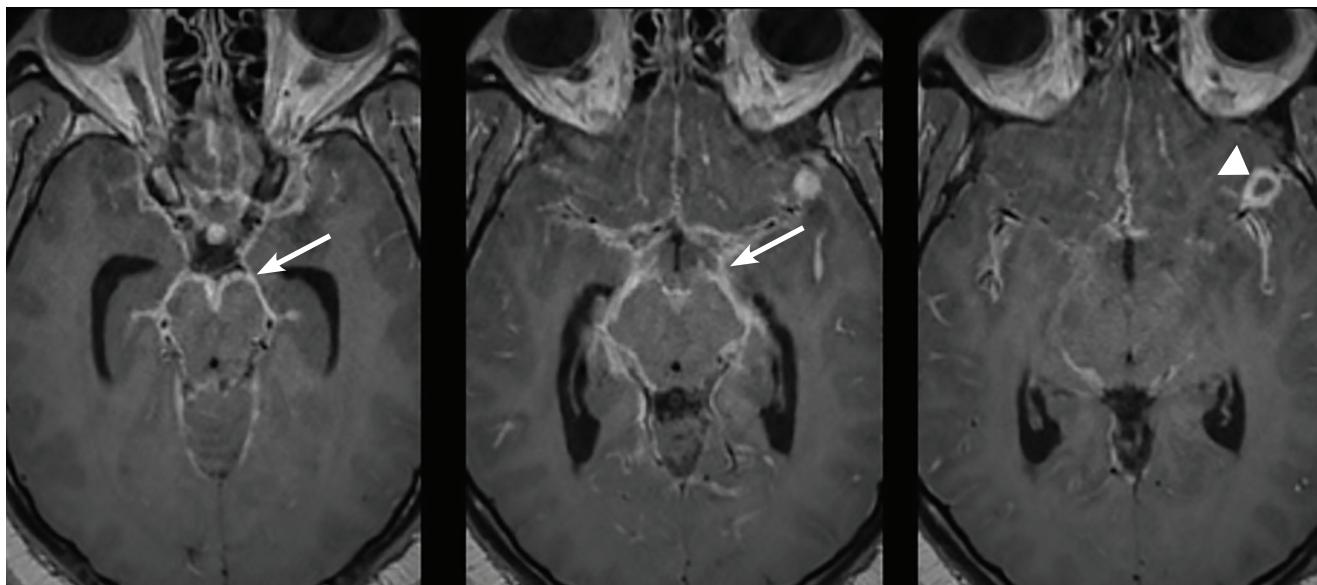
Two weeks later, with the patient’s condition continuing to worsen, magnetic resonance imaging showed bulky leptomeningeal enhancement (arrows), most prominent at the basal surface of the cerebrum, with a peripherally enhancing 1.2-cm lesion at the left sylvian fissure (arrowhead).
